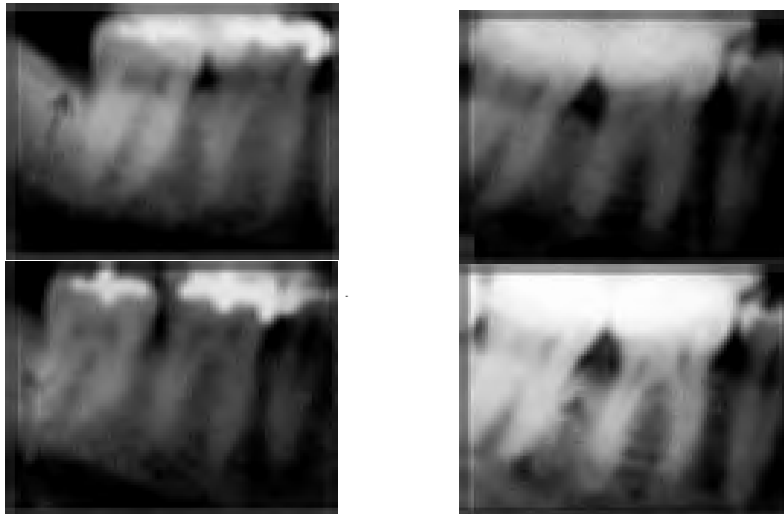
15a and c are baseline radiographics of sites randomized to DFDBA and Accell respectively. 15b and 15d are the results of combination therapy at 12 months post treatment. Used with permission from the author of this thesis, LCDR Teresita Alston.
